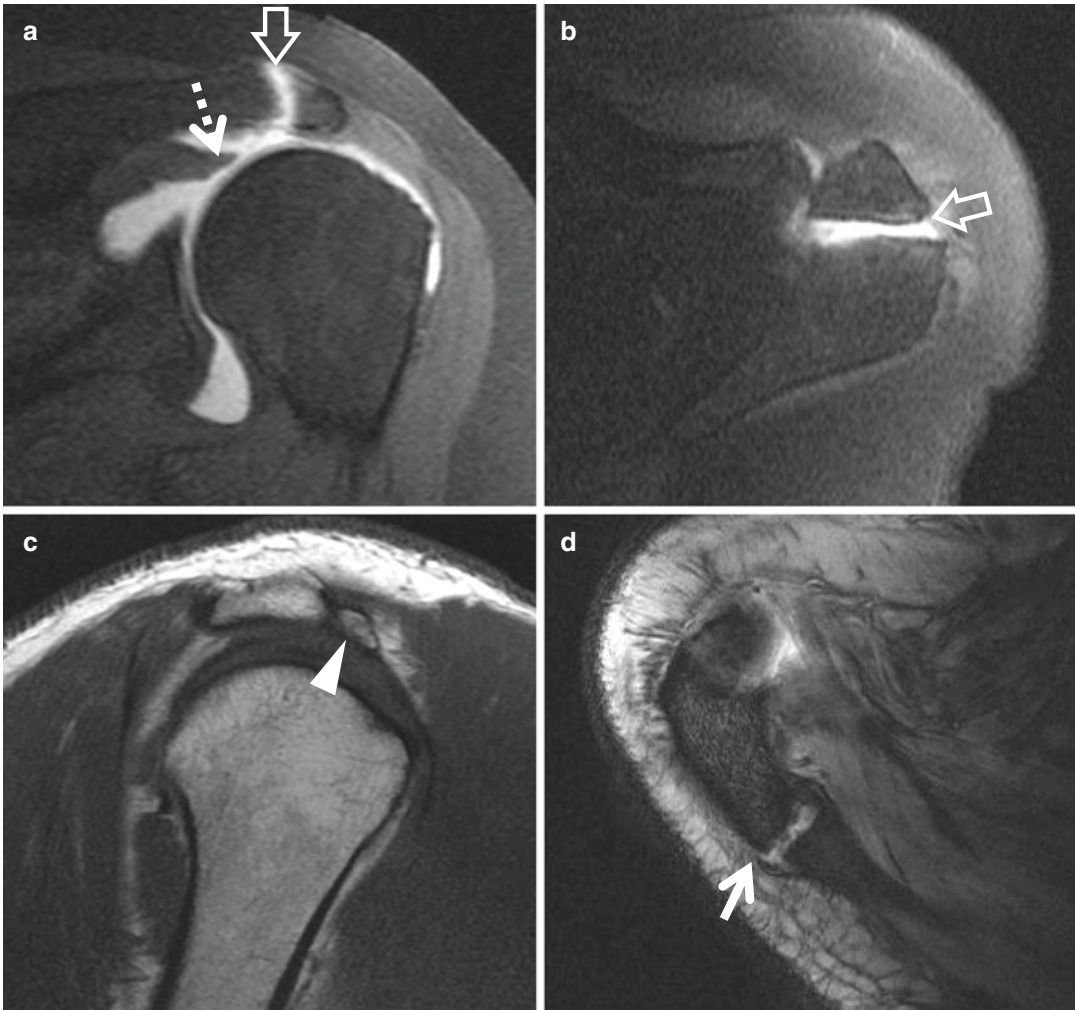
Os acromiale variants in three different patients. (a and b) Coronal oblique and axial T1-weighted fat-suppressed MR images after contrast injection into the glenohumeral joint show communication with the subacromial-subdeltoid bursa through a retracted, full-thickness supraspinatus tendon tear (dashed arrow). In
